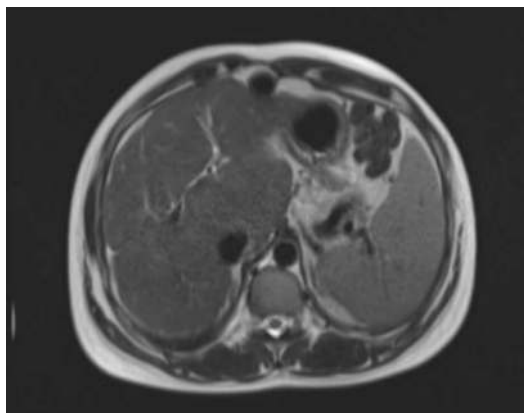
Axial T2-weighted MR image of a 33-year-old chronic BCS patient showing marked caudate lobe hypertrophy
